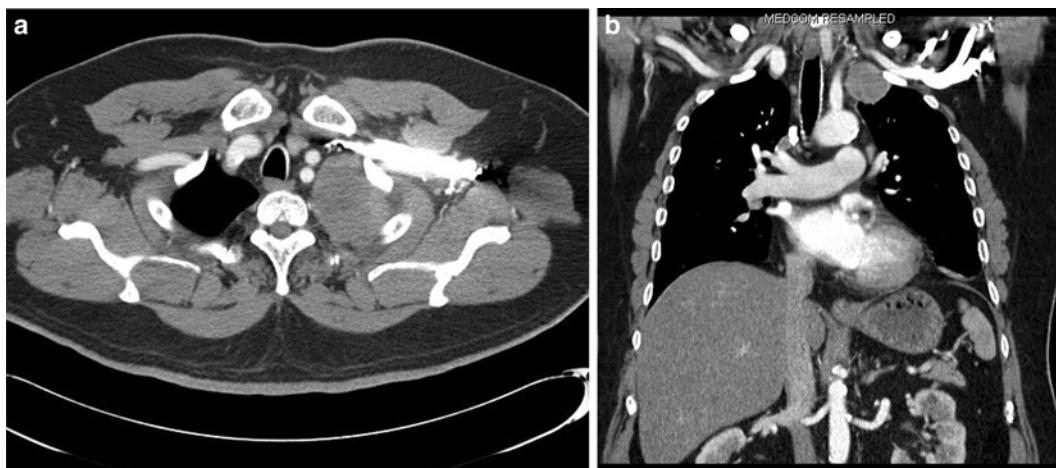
(a, b) Left Pancoast tumor, clinical stage T3 filling superior sulcus but not invading spine or involving subclavian vessels (a). The extent of the tumor is also well defined on the coronal view of the CT scan.
